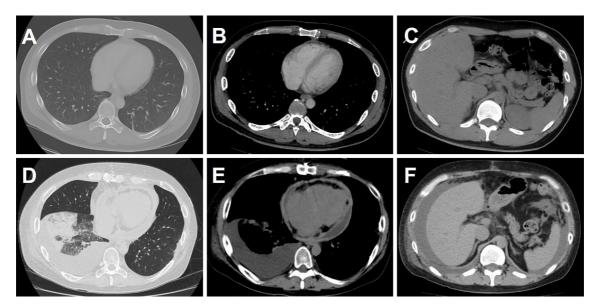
Computed tomography three months prior to (A-C) and upon admission (D-F). Exacerbation of pericardial effusion and new pleural and ascites effusions are demonstrated.
